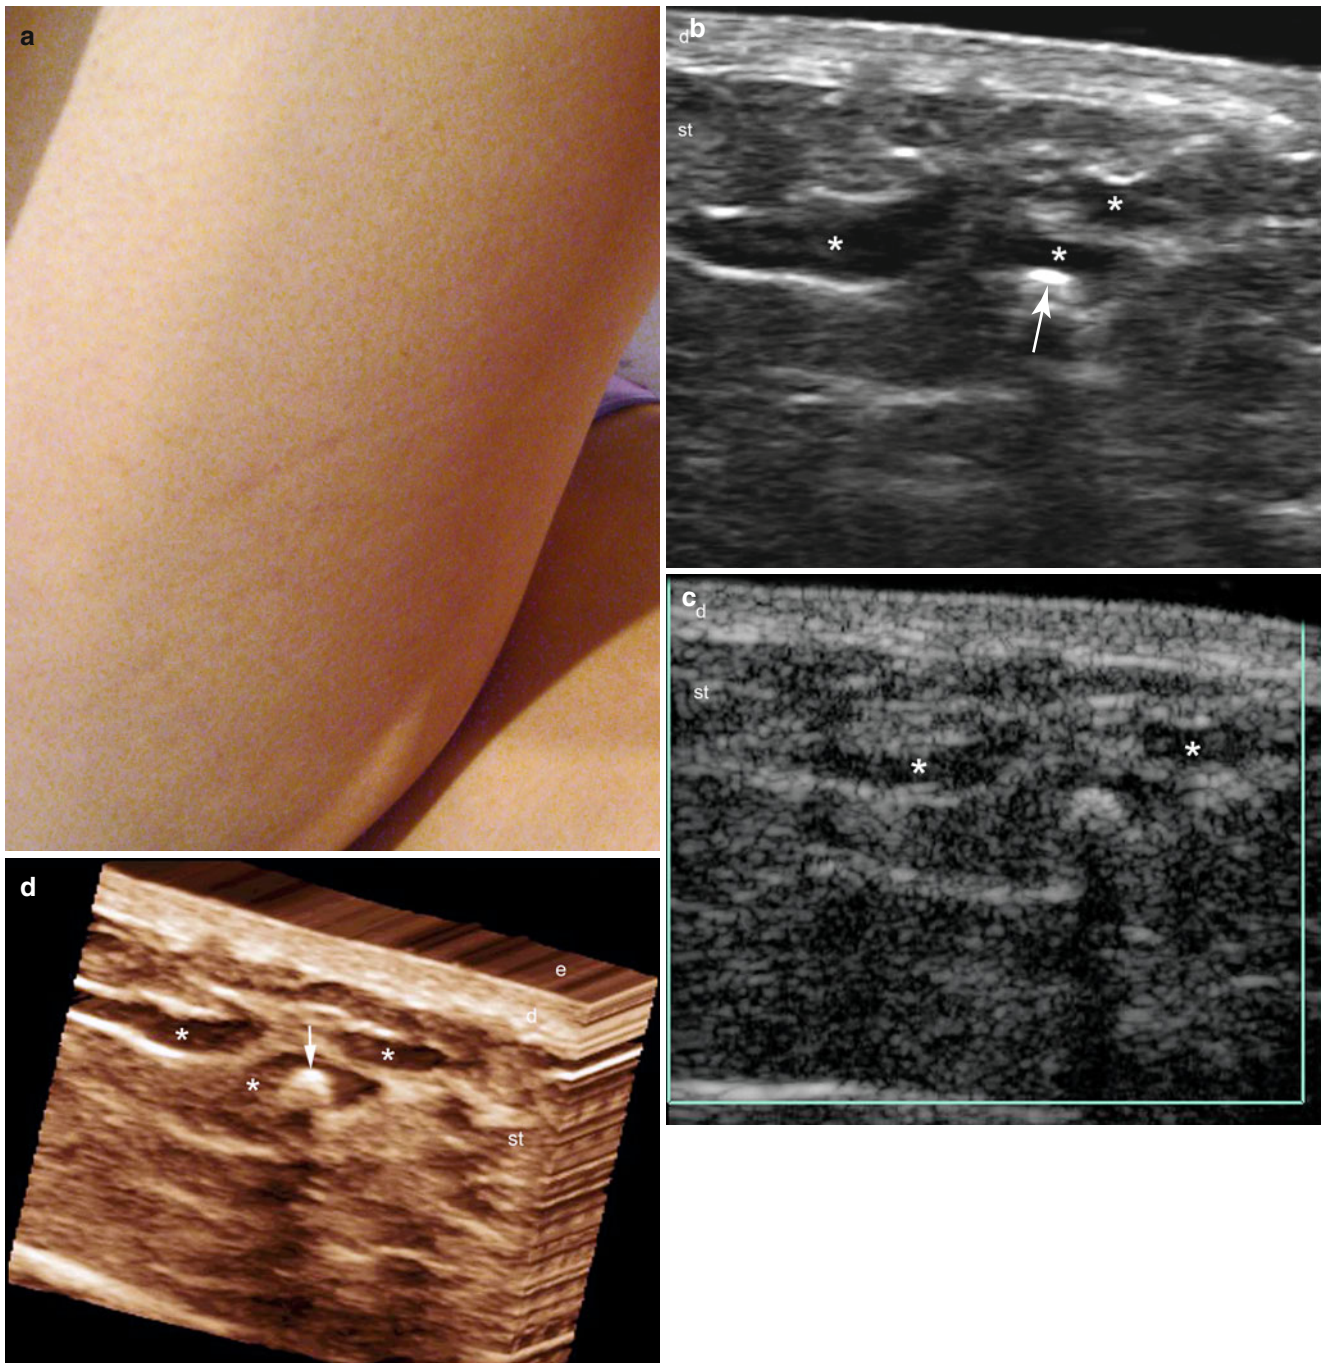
(a–d) Low-flow venous vascular malformation. (a) Clinical lesion demonstrates slight erythema in the posterior aspect of the right thigh. (b) Grey scale ultrasound image (transverse view) shows anechoic ducts (*) in the subcutaneous tissue. Notice the hyperechoic nodule that
